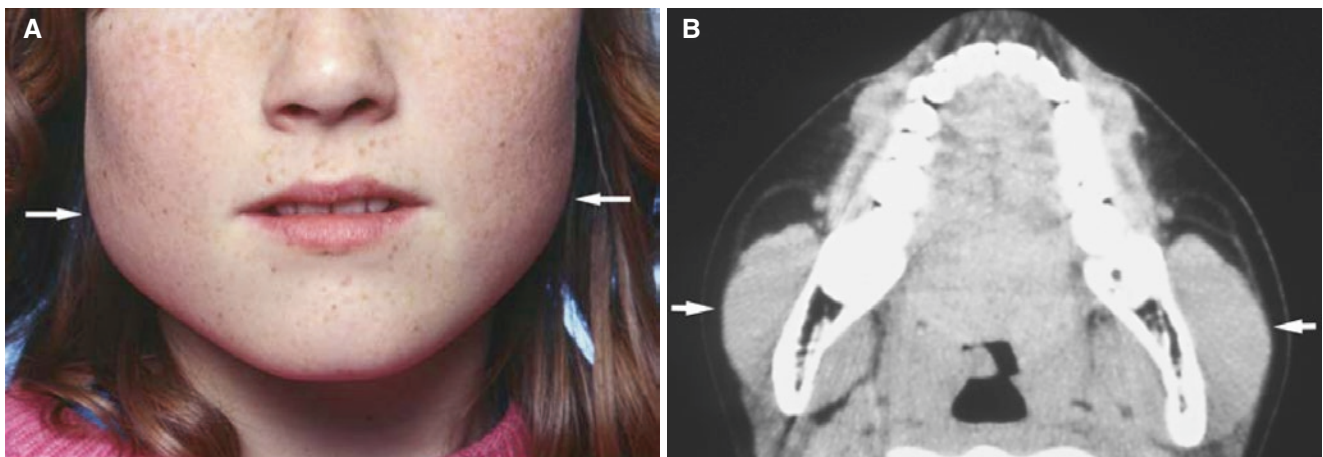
Masseteric hypertrophy; 12-year-old female with bilateral painless swelling of mandibular angles. (A) Clinical photograph shows bilateral swelling of mandibular angles (*arrows*). (B) Axial CT image
